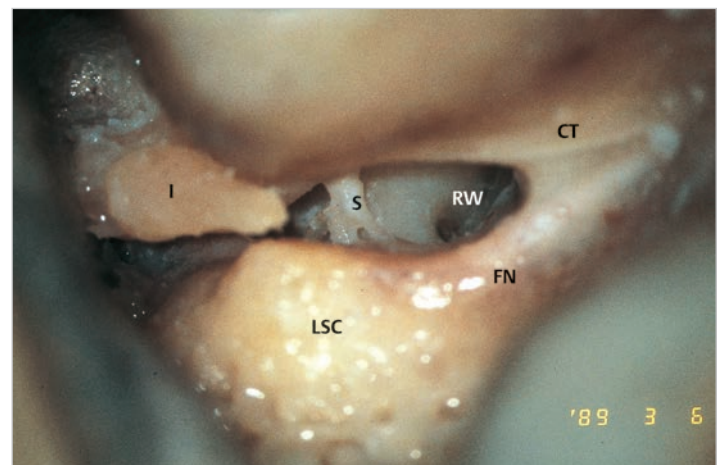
The posterior tympanotomy is completed. The chordal crest and the bony bridge posterior to the incus are removed. The stapes superstructure and the round window niche are now visible. CT, chorda tympani; FN, facial nerve; I, incus; LSC, lateral semicircular canal; RW, round window niche; S, stapes.
